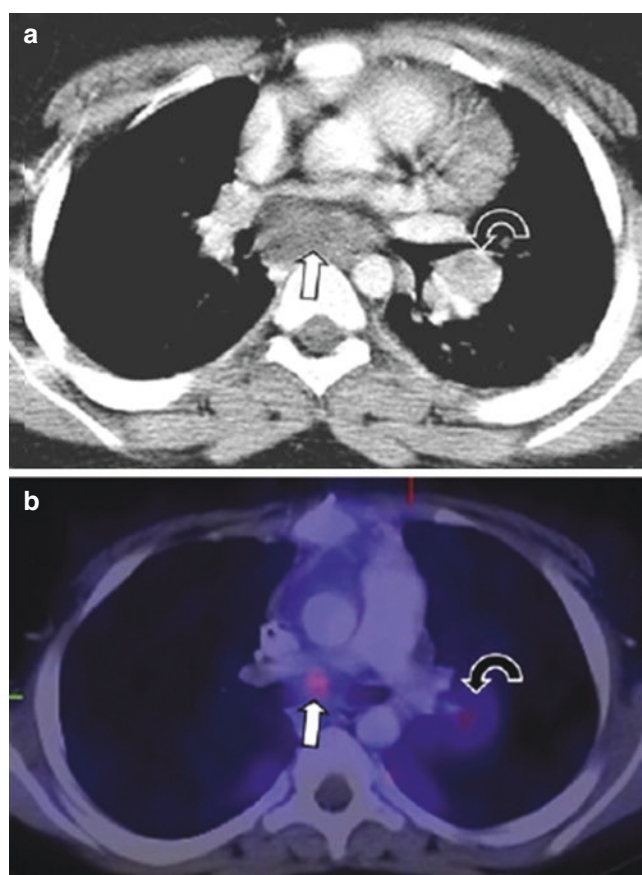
A 10-year-old boy with NUT midline carcinoma (NMC) presented with multiple lower extremity arterial thromboses. Echocardiography showed a possible mediastinal mass, and CT was subsequently performed for further evaluation. (a) Enhanced axial CT image demonstrates a heterogeneously enhancing mass (arrow) located behind the heart with mass effect upon the right inferior pulmonary vein. Also noted is the left hilar lymphadenopathy (curved arrow). (b) Axial CT and PET fusion image shows an increased metabolism in the mediastinal mass (arrow) and left hilar lymphadenopathy (curved arrow)
